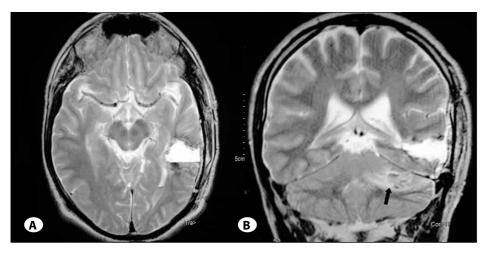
Postoperative axial T2-weighted MR image (A) shows total resection of left temporal cavernoma with small amount of postoperative collection left. Coronal T2-weighted image (B) shows the same collection at left temporal region as well as left cerebellar hemispheric haemorrhage with mild mass effect and minimal adjacent edema (black arrow).
